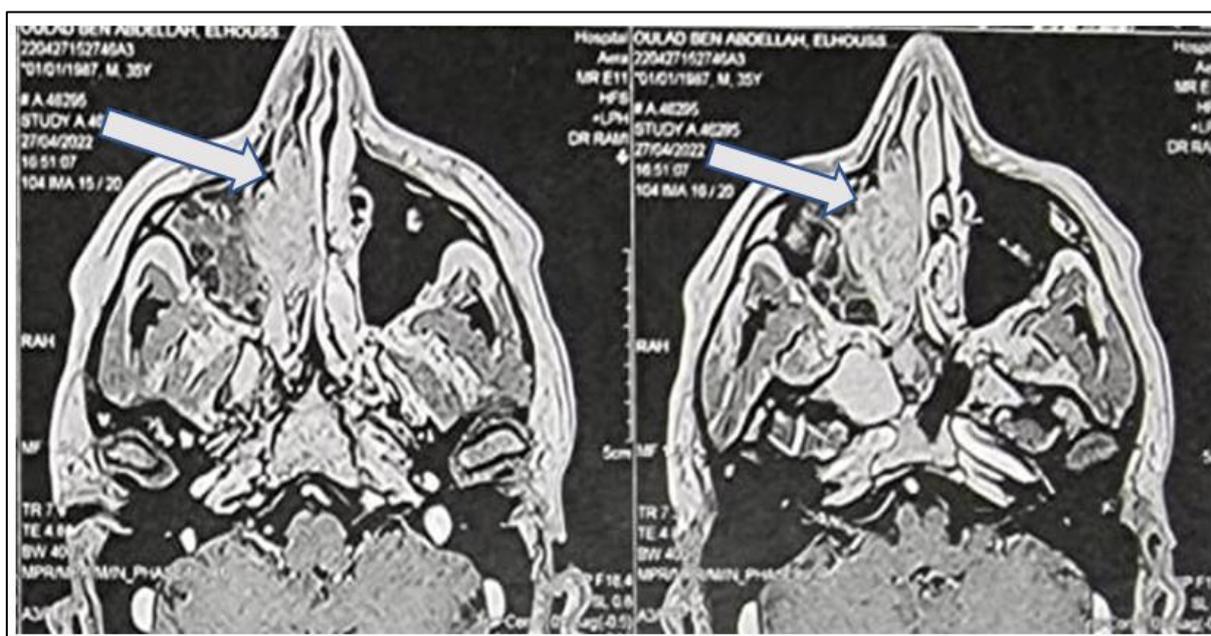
Axial view of MRI head and orbits with contrast demonstrating the right orbital tumor (white arrows) displacing the globe anterolaterally and extending to the paranasal sinuses and left nasal cavity
